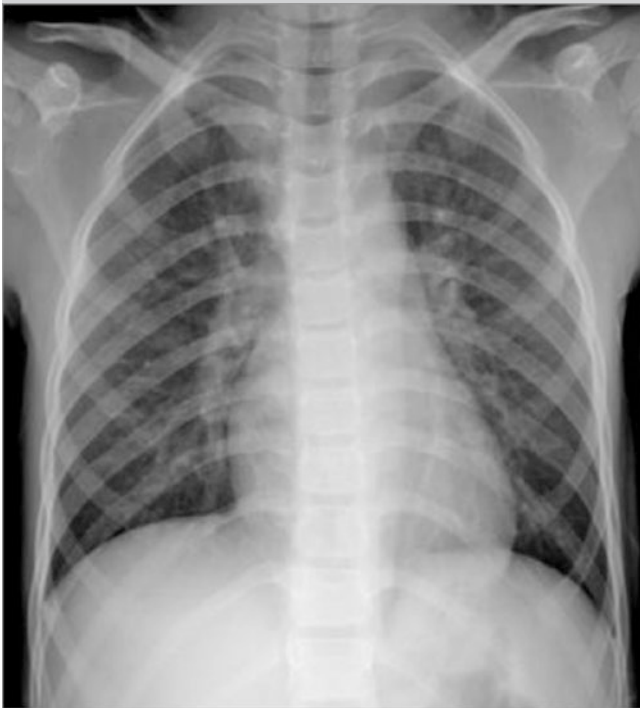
Chest X-ray demonstrated thickened lung markings as well as spots and small flakes of opacities along lung markings in the middle and medial parts of both lung fields
